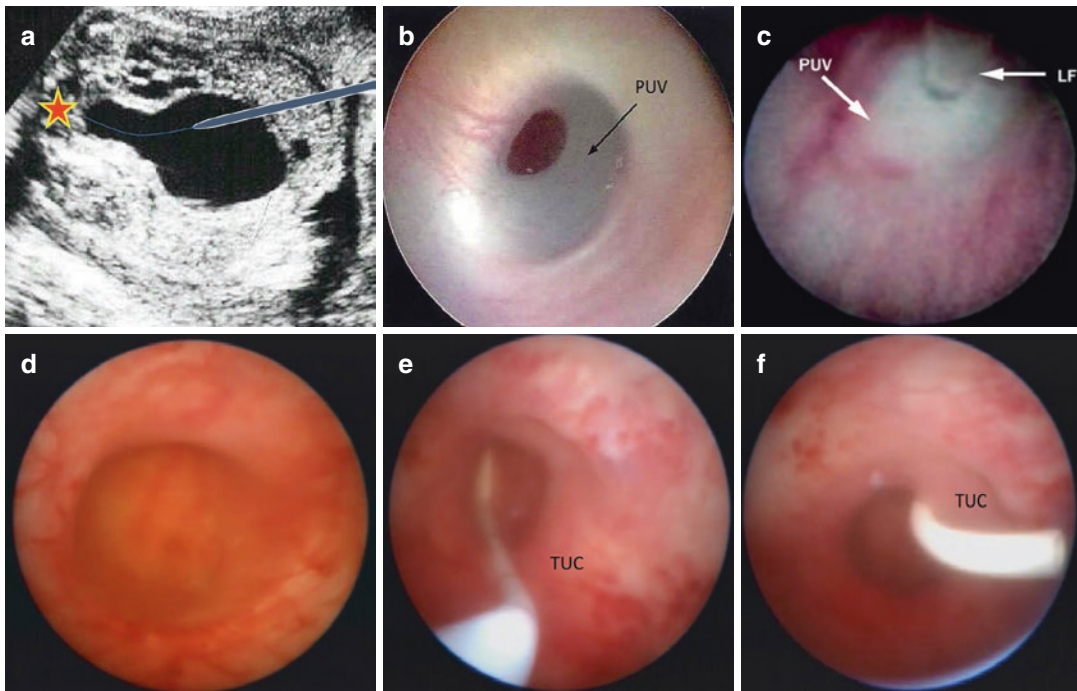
Bladder outlet obstruction. (a) Prenatal ultrasounds detect oligohydramnios, distended bladder, and dilated posterior urethra (keyhole sign). (b) Intraoperative image of posterior urethral valves (PUV). (c) Laser fiber (LF) fulgurating urethral valves. (d) Dilated fetal posterior urethra with difficult visualization of valves. (e) Introduction of a probe catheter through the urethral valves. (f) Double-J transurethral catheter (TUC) in place to decompress fetal urinary tract
